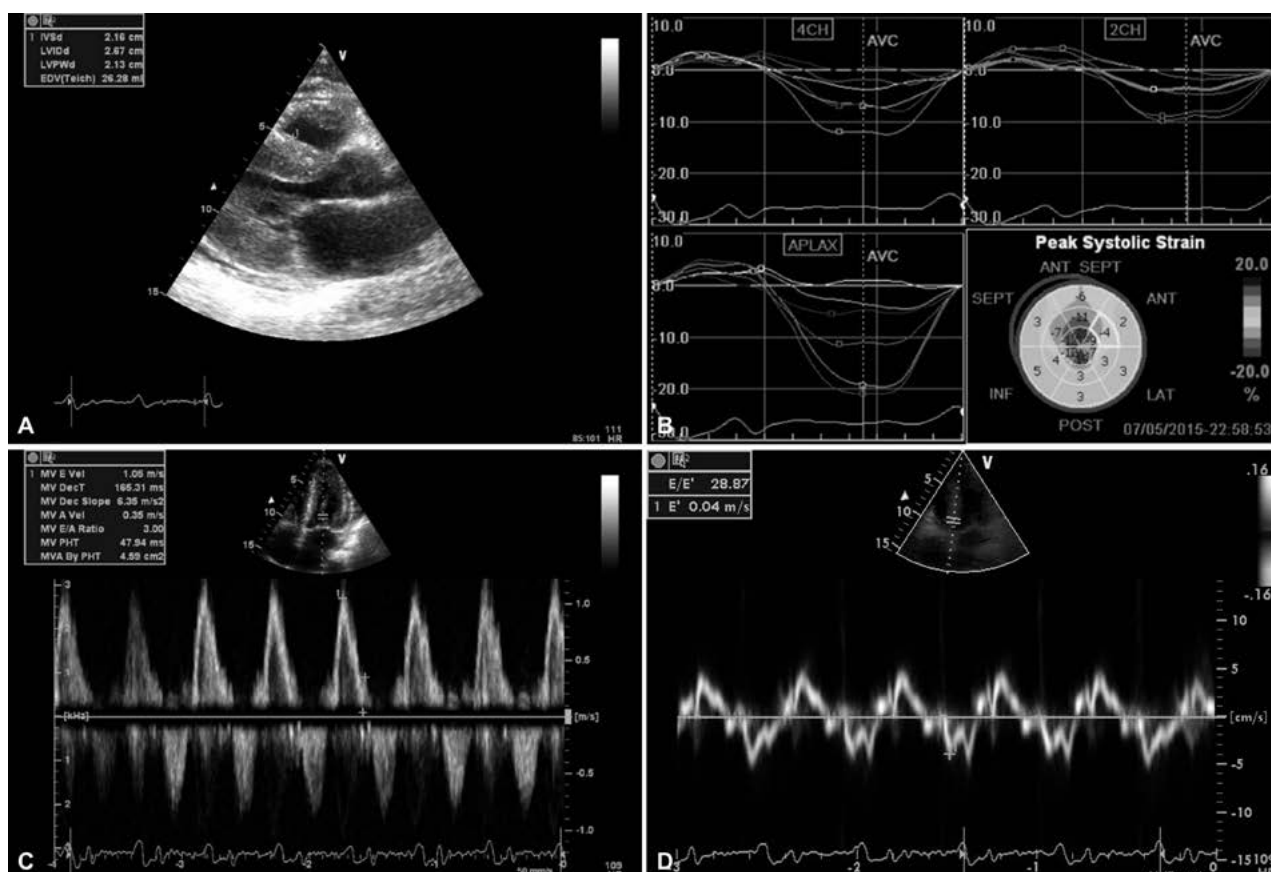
Echocardiogram: A – Parasternal long axis view (still image): thickened left ventricular walls, dilated left atrium and small pericardial effusion. B – Speckle tracking longitudinal strain traces and bull's eye, with typical "apical sparing" pattern. C – Transmitral flow pulsed wave Doppler showing a restrictive pattern. D – Tissue Doppler with low e' and high E/e' ratio, suggestive of high left atrial pressures.
